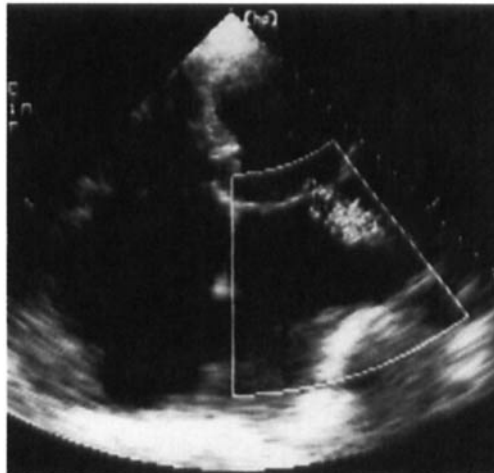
Echocardiography showing severely dilated left atrium, severely dilated right atrium, prolapsed mitral valve, prolapsed tricuspid valve, and mitral regurgitation.
